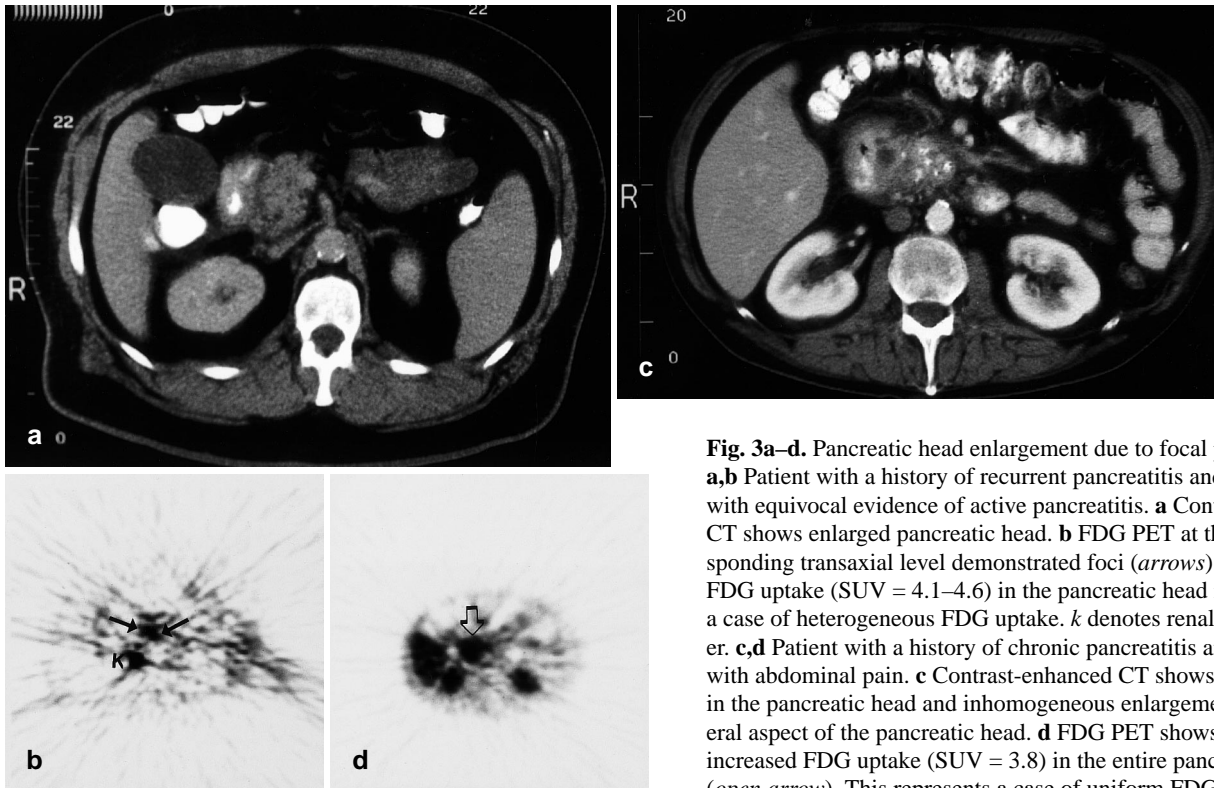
Pancreatic head enlargement due to focal pancreatitis. a,b Patient with a history of recurrent pancreatitis and presenting with equivocal evidence of active pancreatitis. a Contrast-enhanced CT shows enlarged pancreatic head. b FDG PET at the corresponding transaxial level demonstrated foci (arrows) of increased FDG uptake (SUV = 4.1–4.6) in the pancreatic head mass. This is a case of heterogeneous FDG uptake. *k* denotes renal urinary tracer. c,d Patient with a history of chronic pancreatitis and presenting with abdominal pain. c Contrast-enhanced CT shows calcifications in the pancreatic head and inhomogeneous enlargement of the lateral aspect of the pancreatic head. d FDG PET shows uniformly increased FDG uptake (SUV = 3.8) in the entire pancreatic head (open arrow). This represents a case of uniform FDG uptake
